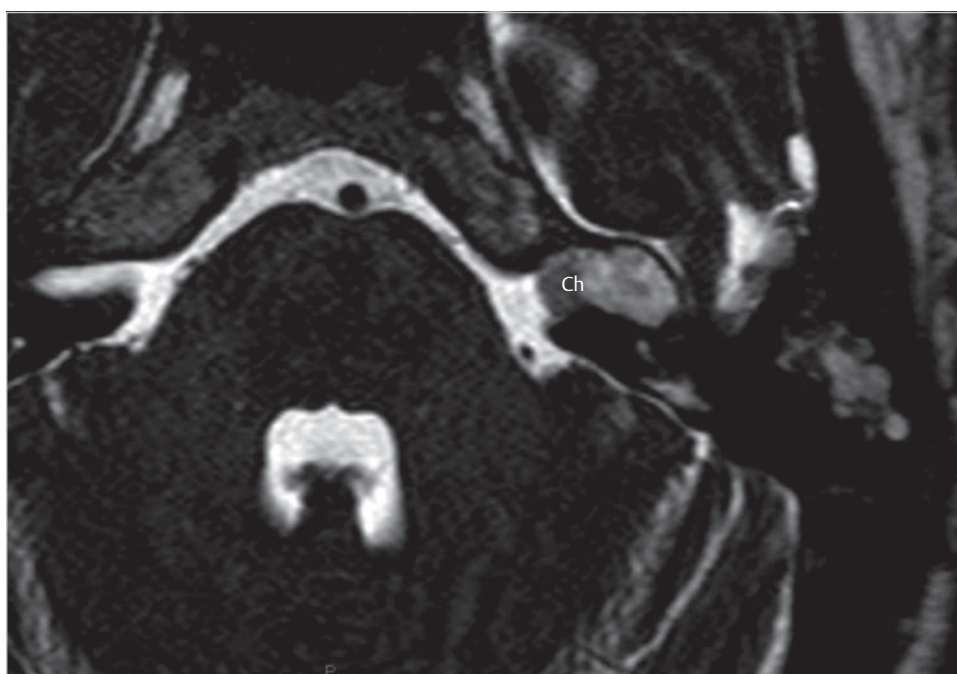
The axial section of heavy T2-weighted MRI clearly demonstrates extension of the cholesteatoma into the internal auditory canal. Ch, cholesteatoma.
